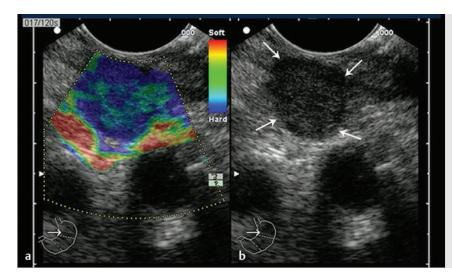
Endoscopic ultrasound (EUS) of perigastric lymph node (*arrows*). (a) Strain elastogram and (b) corresponding B-mode image. The elastogram shows hard areas (blue) covering approximately>45% of the node. The B-mode image shows a rounded node with loss of hilar echoes. The findings suggest malignancy. (Image courtesy of Dr Pankaj Dhawan, Mumbai, India.)
